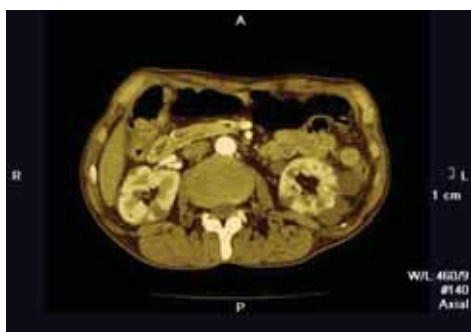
Original CT image with kidney cysts
